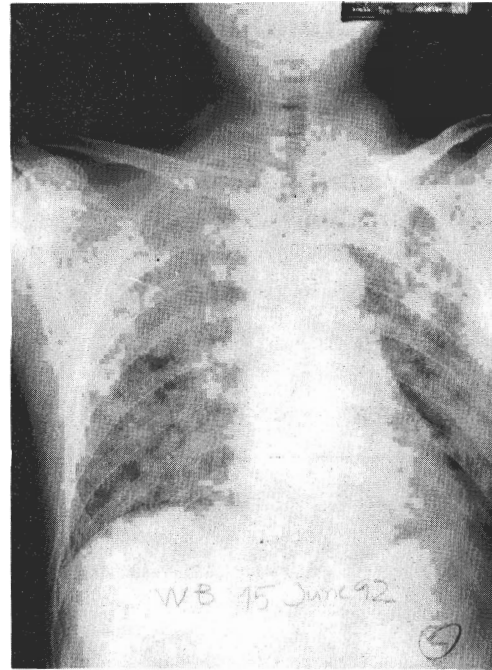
A chest radiograph taken on June 15, 1992 showing fine reticulo-nodular infiltrates diffusely distributed in both lungs.
